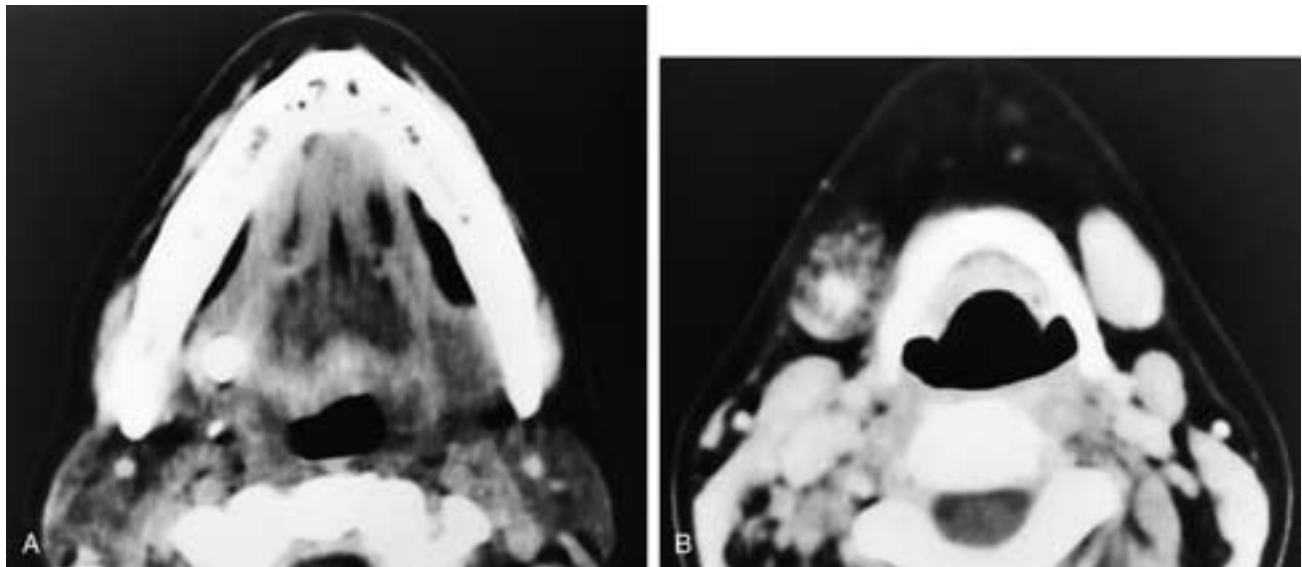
Axial contrast-enhanced CT scans (A, B) show a calculus near the hilum of the right submandibular gland. There is also some inflammatory thickening of the right mylohyoid muscle. In B, a more caudal scan, the lower portion of the calcification is seen in a somewhat diffusely fatty, atrophic gland. This patient had chronic submandibular sialolithiasis, sialadenitis, and early glandular atrophy.
